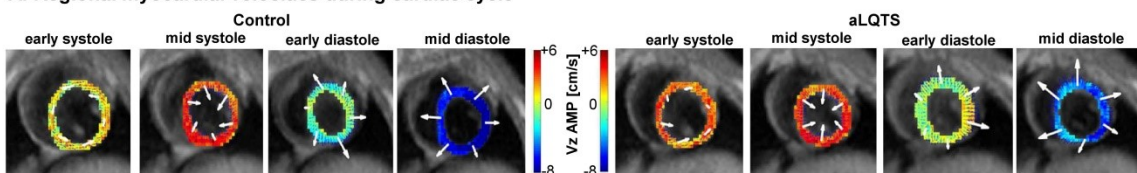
Impact of electrical alterations (aLQTS) on mechanical function (via EMC) in tissue-phase mapping MRI (TPM-MR). A. Example of regional longitudinal velocities (V_z AMP, cm/s, color-coded as indicated) and radial velocities (indicated by length of arrows) during cardiac cycle in control and aLQTS. B. Bull's eye plots of diastolic peak longitudinal velocities (V_z AMPdia, cm/s) in all basal, mid, and apical segments. Velocities are color-coded and average values are indicated. Diastolic peak longitudinal velocities decreased in 9 out of 16 segments as indicated in the arrow (n=19 each). C. Bull's eye plots of regional time-to diastolic peak duration in longitudinal velocities (V_z TTPdia, cm/s). V_z TTPdia increased in 9 out of 16 segments as indicated in the arrow (n=9 each). Velocities are color-coded as indicated. D. Exemplary myocardial longitudinal velocity curve in base (V_z AMP
